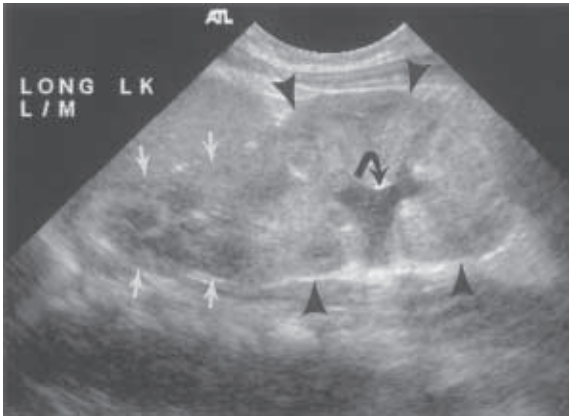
Pyelonephritis. The sonographic findings suggest an etiology. The upper pole of the kidney (arrows) appears normal. Parenchyma of the lower pole (arrowheads) is enlarged with slight dilatation of the collecting system (curved arrow). Findings are consistent with duplication with lower pole pyelonephritis, likely secondary to reflux.
